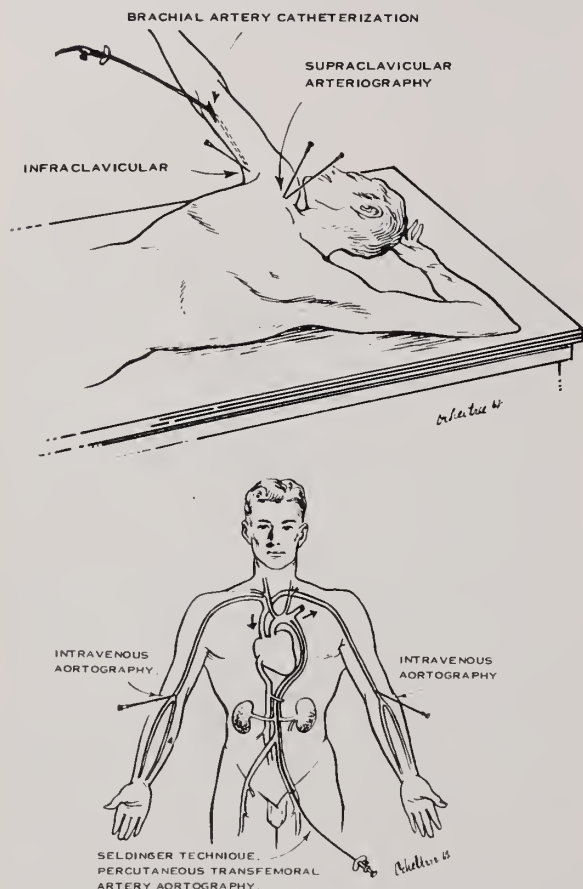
Methods of x-ray visualization of the supra-aortic trunk and upper extremity arteries.
